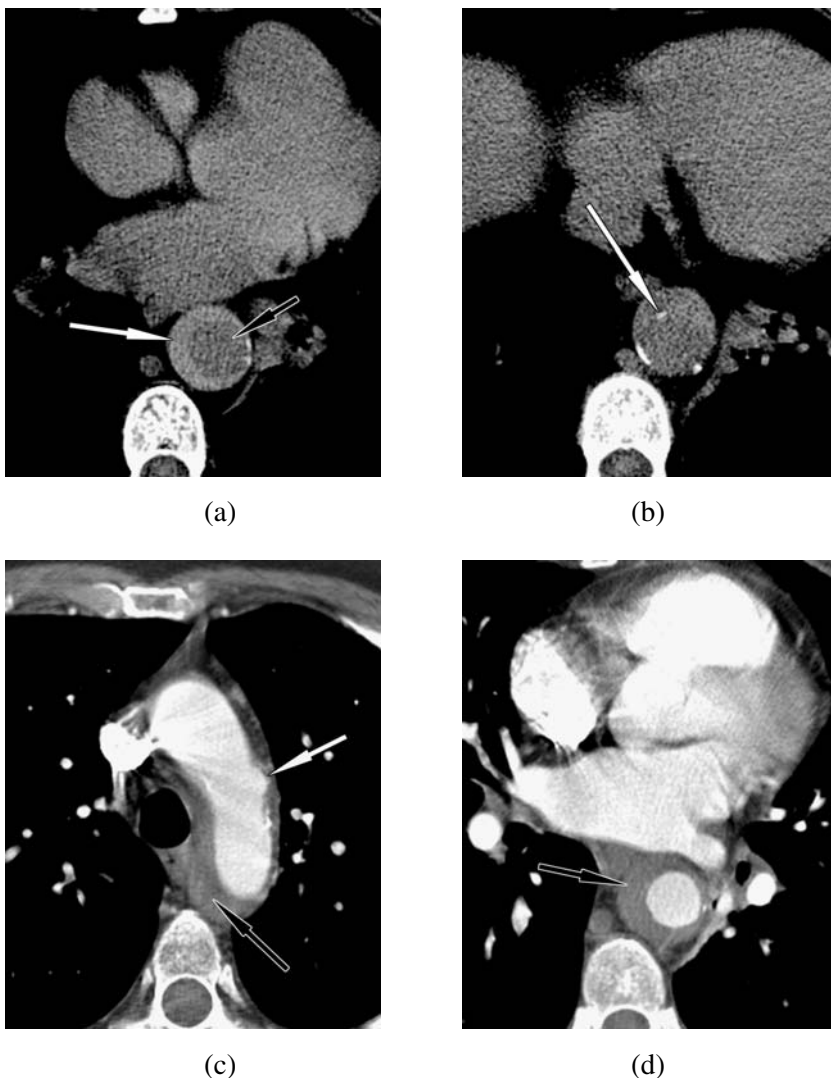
CT examination of type B intramural hematoma (IMH): (a) unenhanced axial image shows higher attenuation of acute intramural hematoma (white arrow), compared to low attenuation of the perfused true lumen of the aorta (black arrow); (b) unenhanced axial image inferior to (a) shows displaced intima calcification (white arrow); (c) axial contrast-enhanced image of the aortic arch shows low attenuation of the intramural hematoma (black arrow), compared to the contrast filled true lumen of the aorta; a focal contrast outpouching of the true lumen (white arrow) suggests intimal tear or ulceration; (d–e) axial contrast enhanced images at the same level as (a) and (b) demonstrate intramural hematoma of the descending thoracic aorta (black arrow); (f) maximum intensity projection reformatted image nicely demonstrates the extent of the intramural thrombus (black arrows), however, does not add additional diagnostic information.
